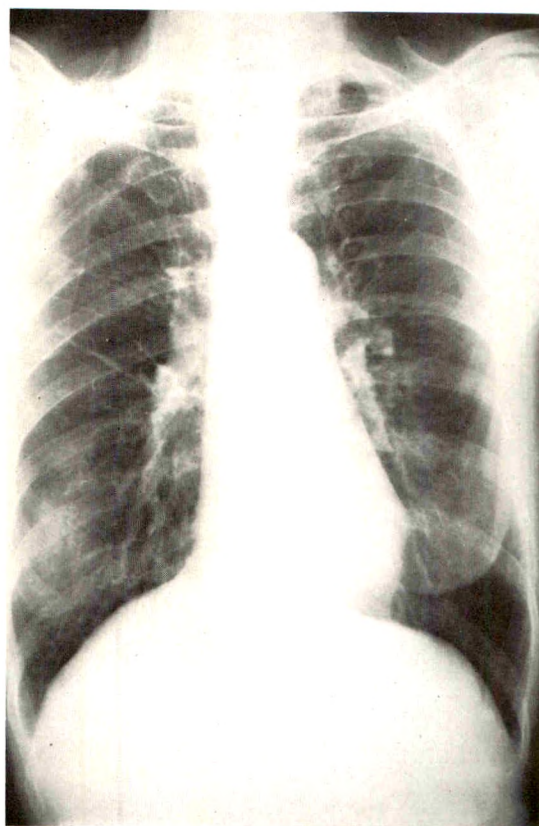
Roentgenologic diagnosis of senile emphysema, based on this single roentgenogram. There was no investigation of diaphragmatic motion, size of chest or status of the patient.
